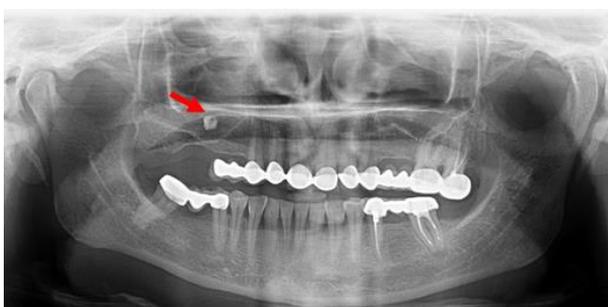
Panoramic radiograph showing the radiopaque mass in the right maxillary sinus.
